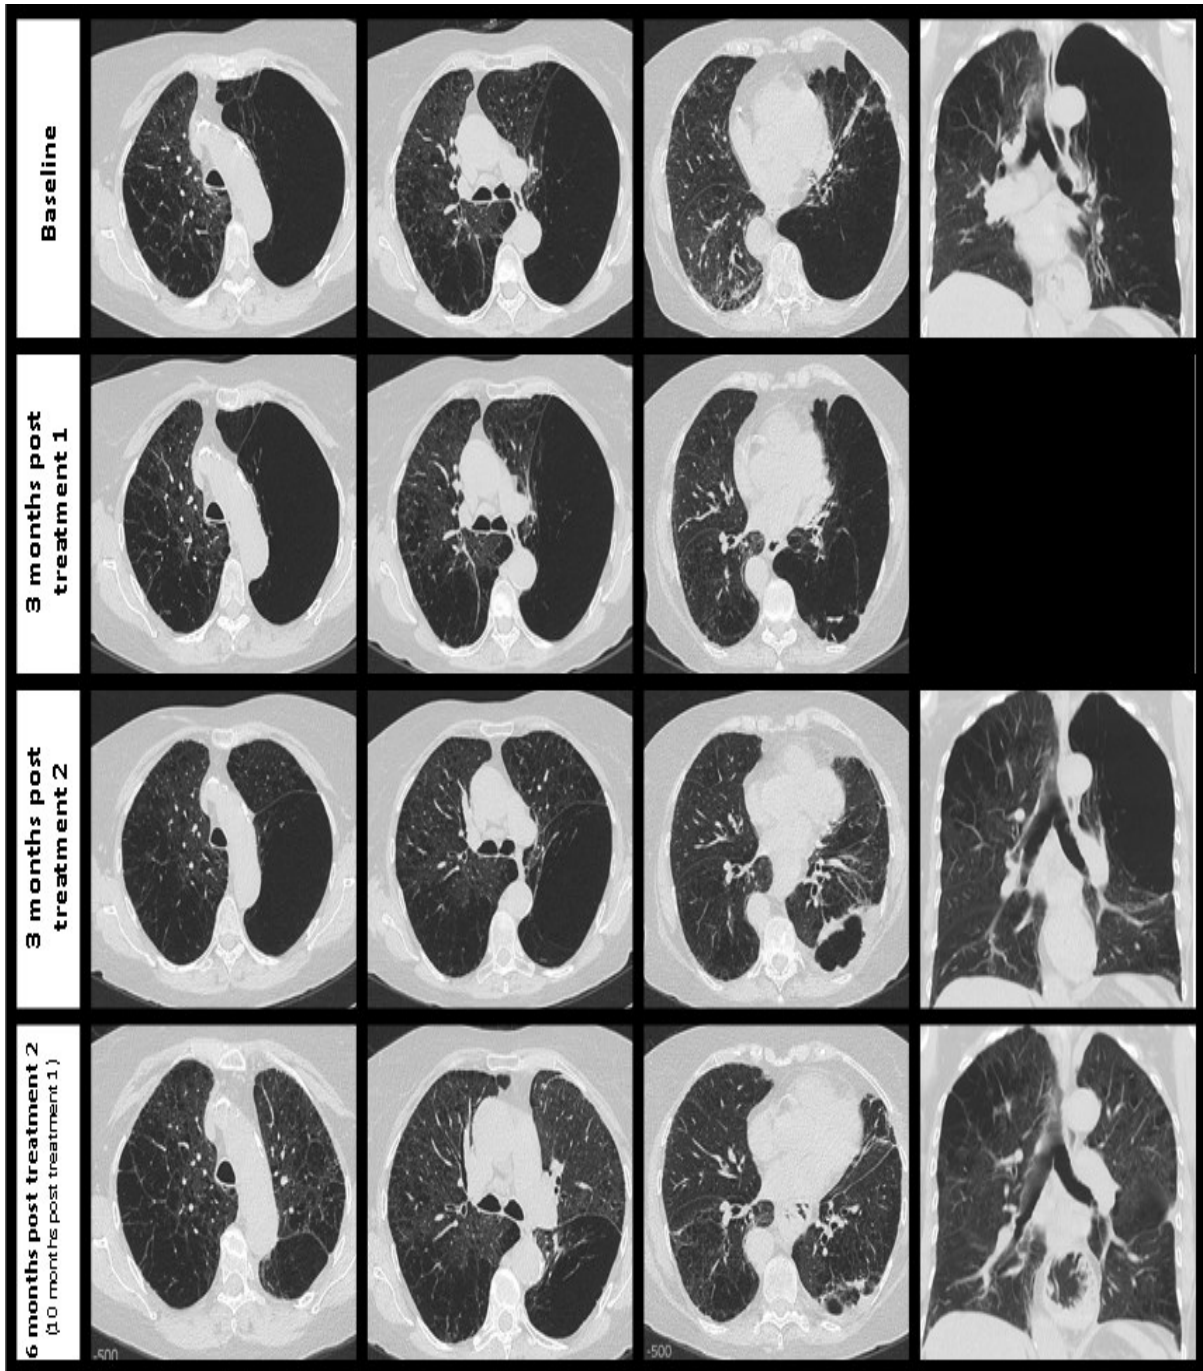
HRCT scan images for subject 5 at the levels of the aortic arch, the carina and T7 vertebra, as well as coronal views 3 months after the first, and 3 and 6 months after the second treatment (10 months after the first treatment). These demonstrate shrinkage of the giant bulla with re-expansion of the upper lobe and shifting of the mediastinum towards the treated lung.
